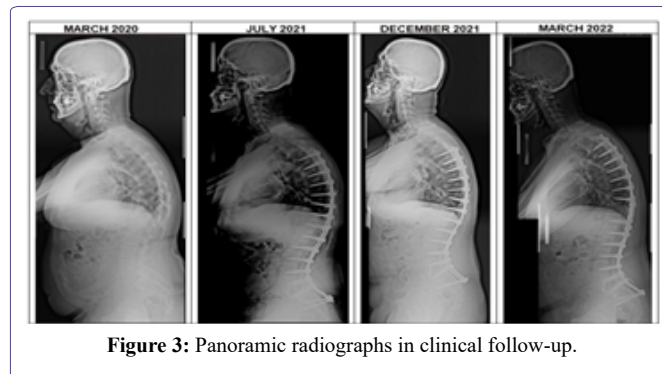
Panoramic radiographs in clinical follow-up.
